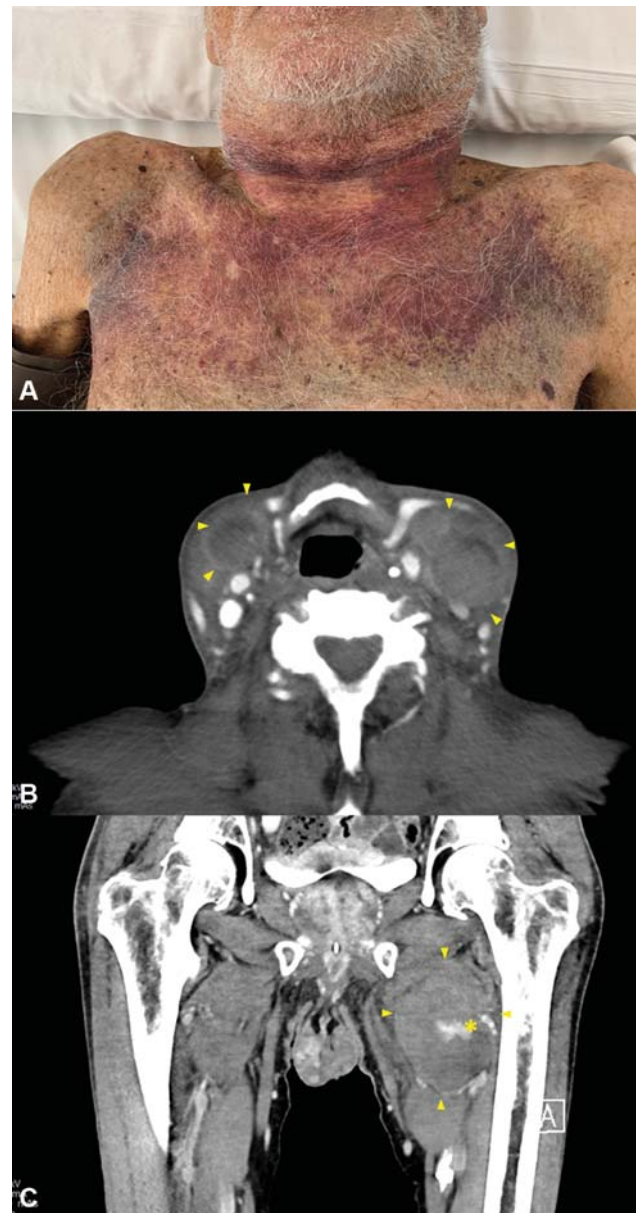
(A) Photo showing the extension of subcutaneous hematomas. Contrast-enhanced CT (computed tomography) images showing hemorrhagic infarction (arrowheads) and tissue distortion of both sternocleidomastoid muscles, more prominent on the left one, in the cervical region (B) and the hematoma of the left abductors district (C) with minor intraslesional contrast extravasation (asterisk).
